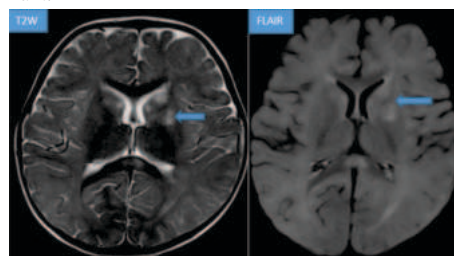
Bilateral basal ganglia hyperintensities on T2W/FLAIR sequences in a case hypoxic ischaemic encephalopathy in a term infant.
